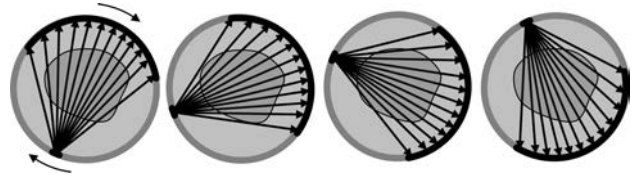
Ultrasound transmission tomography arrangement with fan-beams.
